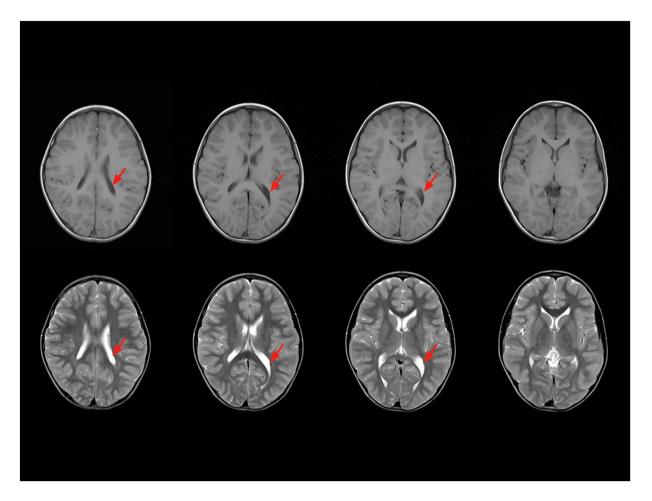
Brain MR images. Red arrows indicates suggested area of PVL.
